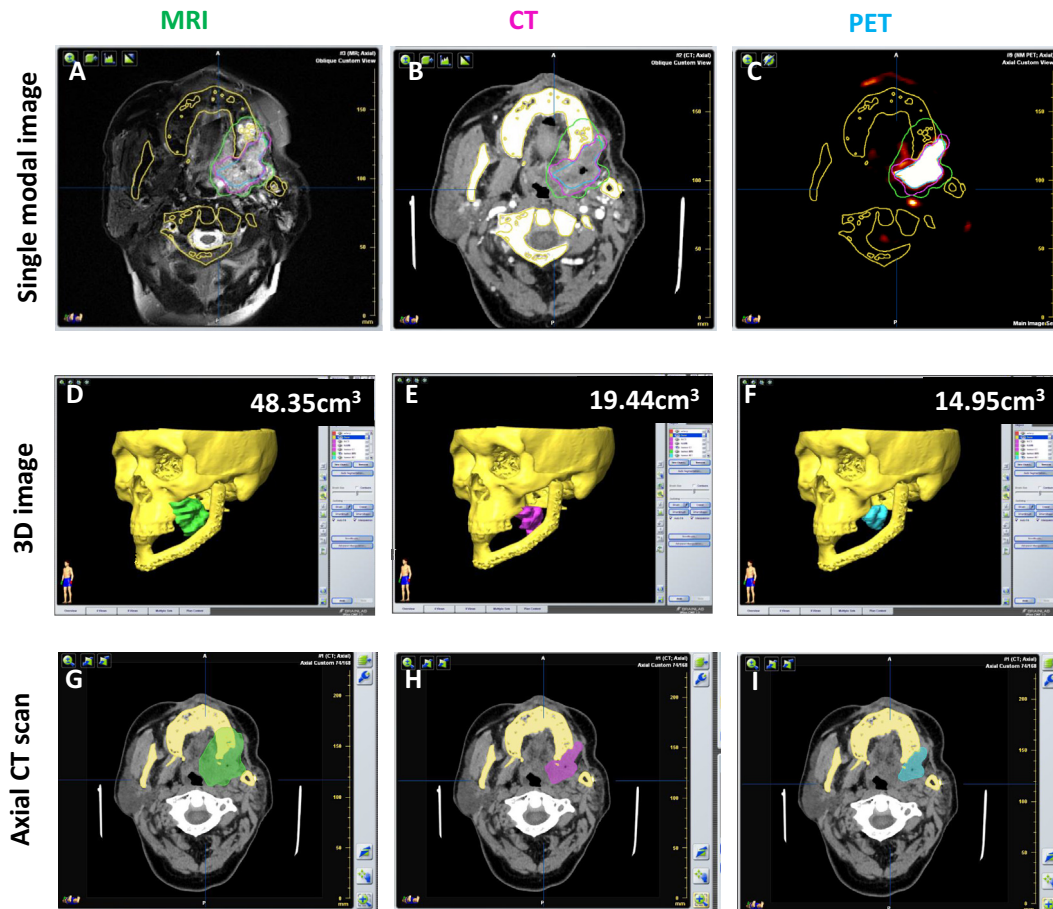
Tumor volume comparison for case 1, with infratemporal fossa malignancies monitored by contrast CT, MR imaging, and PET. (A–C) The tumor is indicated in green (contrast CT), purple (MR imaging), and blue (PET), using imaging data based on the same coordinate system. (D–I) Tumor counters derived from contrast CT, MR imaging, and PET data displayed in 3D image and axial CT image form. GTVs for case 1 calculated from different imaging data are labeled in Figures D–F.
